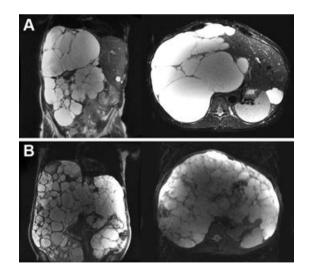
Magnetic resonance imaging for polycystic liver disease patients. Panel A: Coronal and axial cross section of a patient that was eligible for partial hepatectomy and cyst fenestration (PHCF). Panel B: Coronal and axial cross section of a patient that was not eligible for PHCF as there were no areas of relatively normal liver parenchyma.
